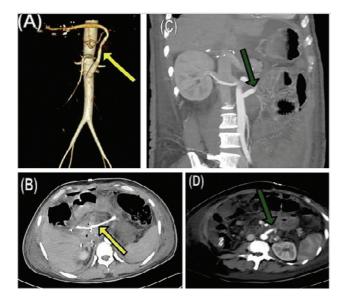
In the same patient, virtual reconstructed image (A) shows infrarenal aorto-hepatic jump graft (yellow arrow) after ligating the native hepatic artery. Contrast-enhanced computed tomography (CECT) axial sections (B) of the upper abdomen show linear contrast opacification of aorto-hepatic jump graft (yellow arrow). Mild ascites with mesenteric haziness is also noted. Following deranged lab parameters repeat CECT images in coronal and axial planes (C and D) showed nonopacification of the jump graft (green arrow) consistent with complete thrombosis of the extrahepatic portions of jump graft.
